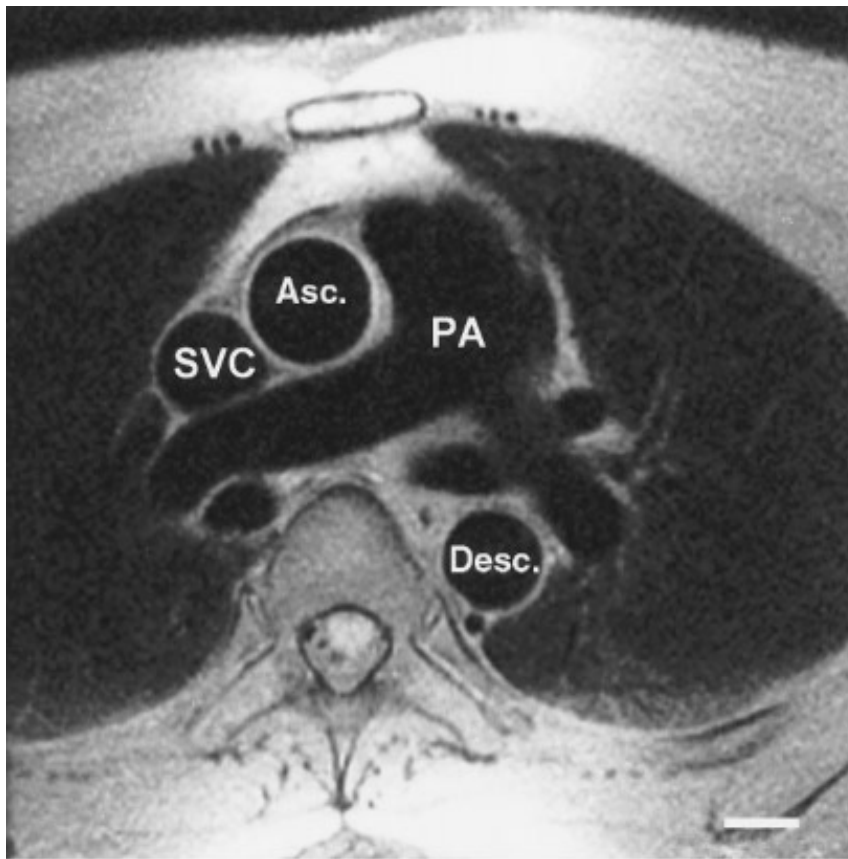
Double-inversion recovery, fast spin-echo, proton-density-weighted magnetic resonance image from a normal subject. The signal from blood is suppressed, and therefore, the lumen is dark. The aortic wall of the ascending (Asc.) and descending (Desc.) aorta is clearly seen. PA = pulmonary artery; SVC = superior vena cava.
